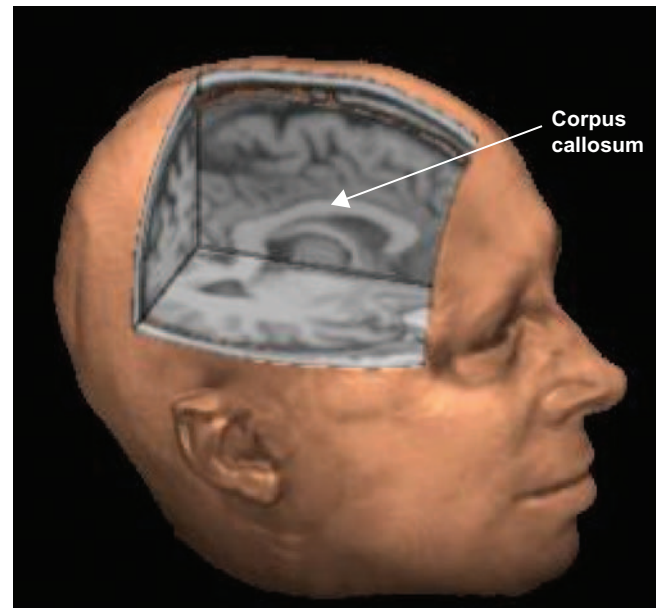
A cut-away of a three-dimensional magnetic resonance image showing the location of the corpus callosum – a white fiber arch extending horizontally from the anterior of the brain to the posterior, forming a fiber link between the two hemispheres. *Source:* Mark Dow, University of Oregon, with permission.
